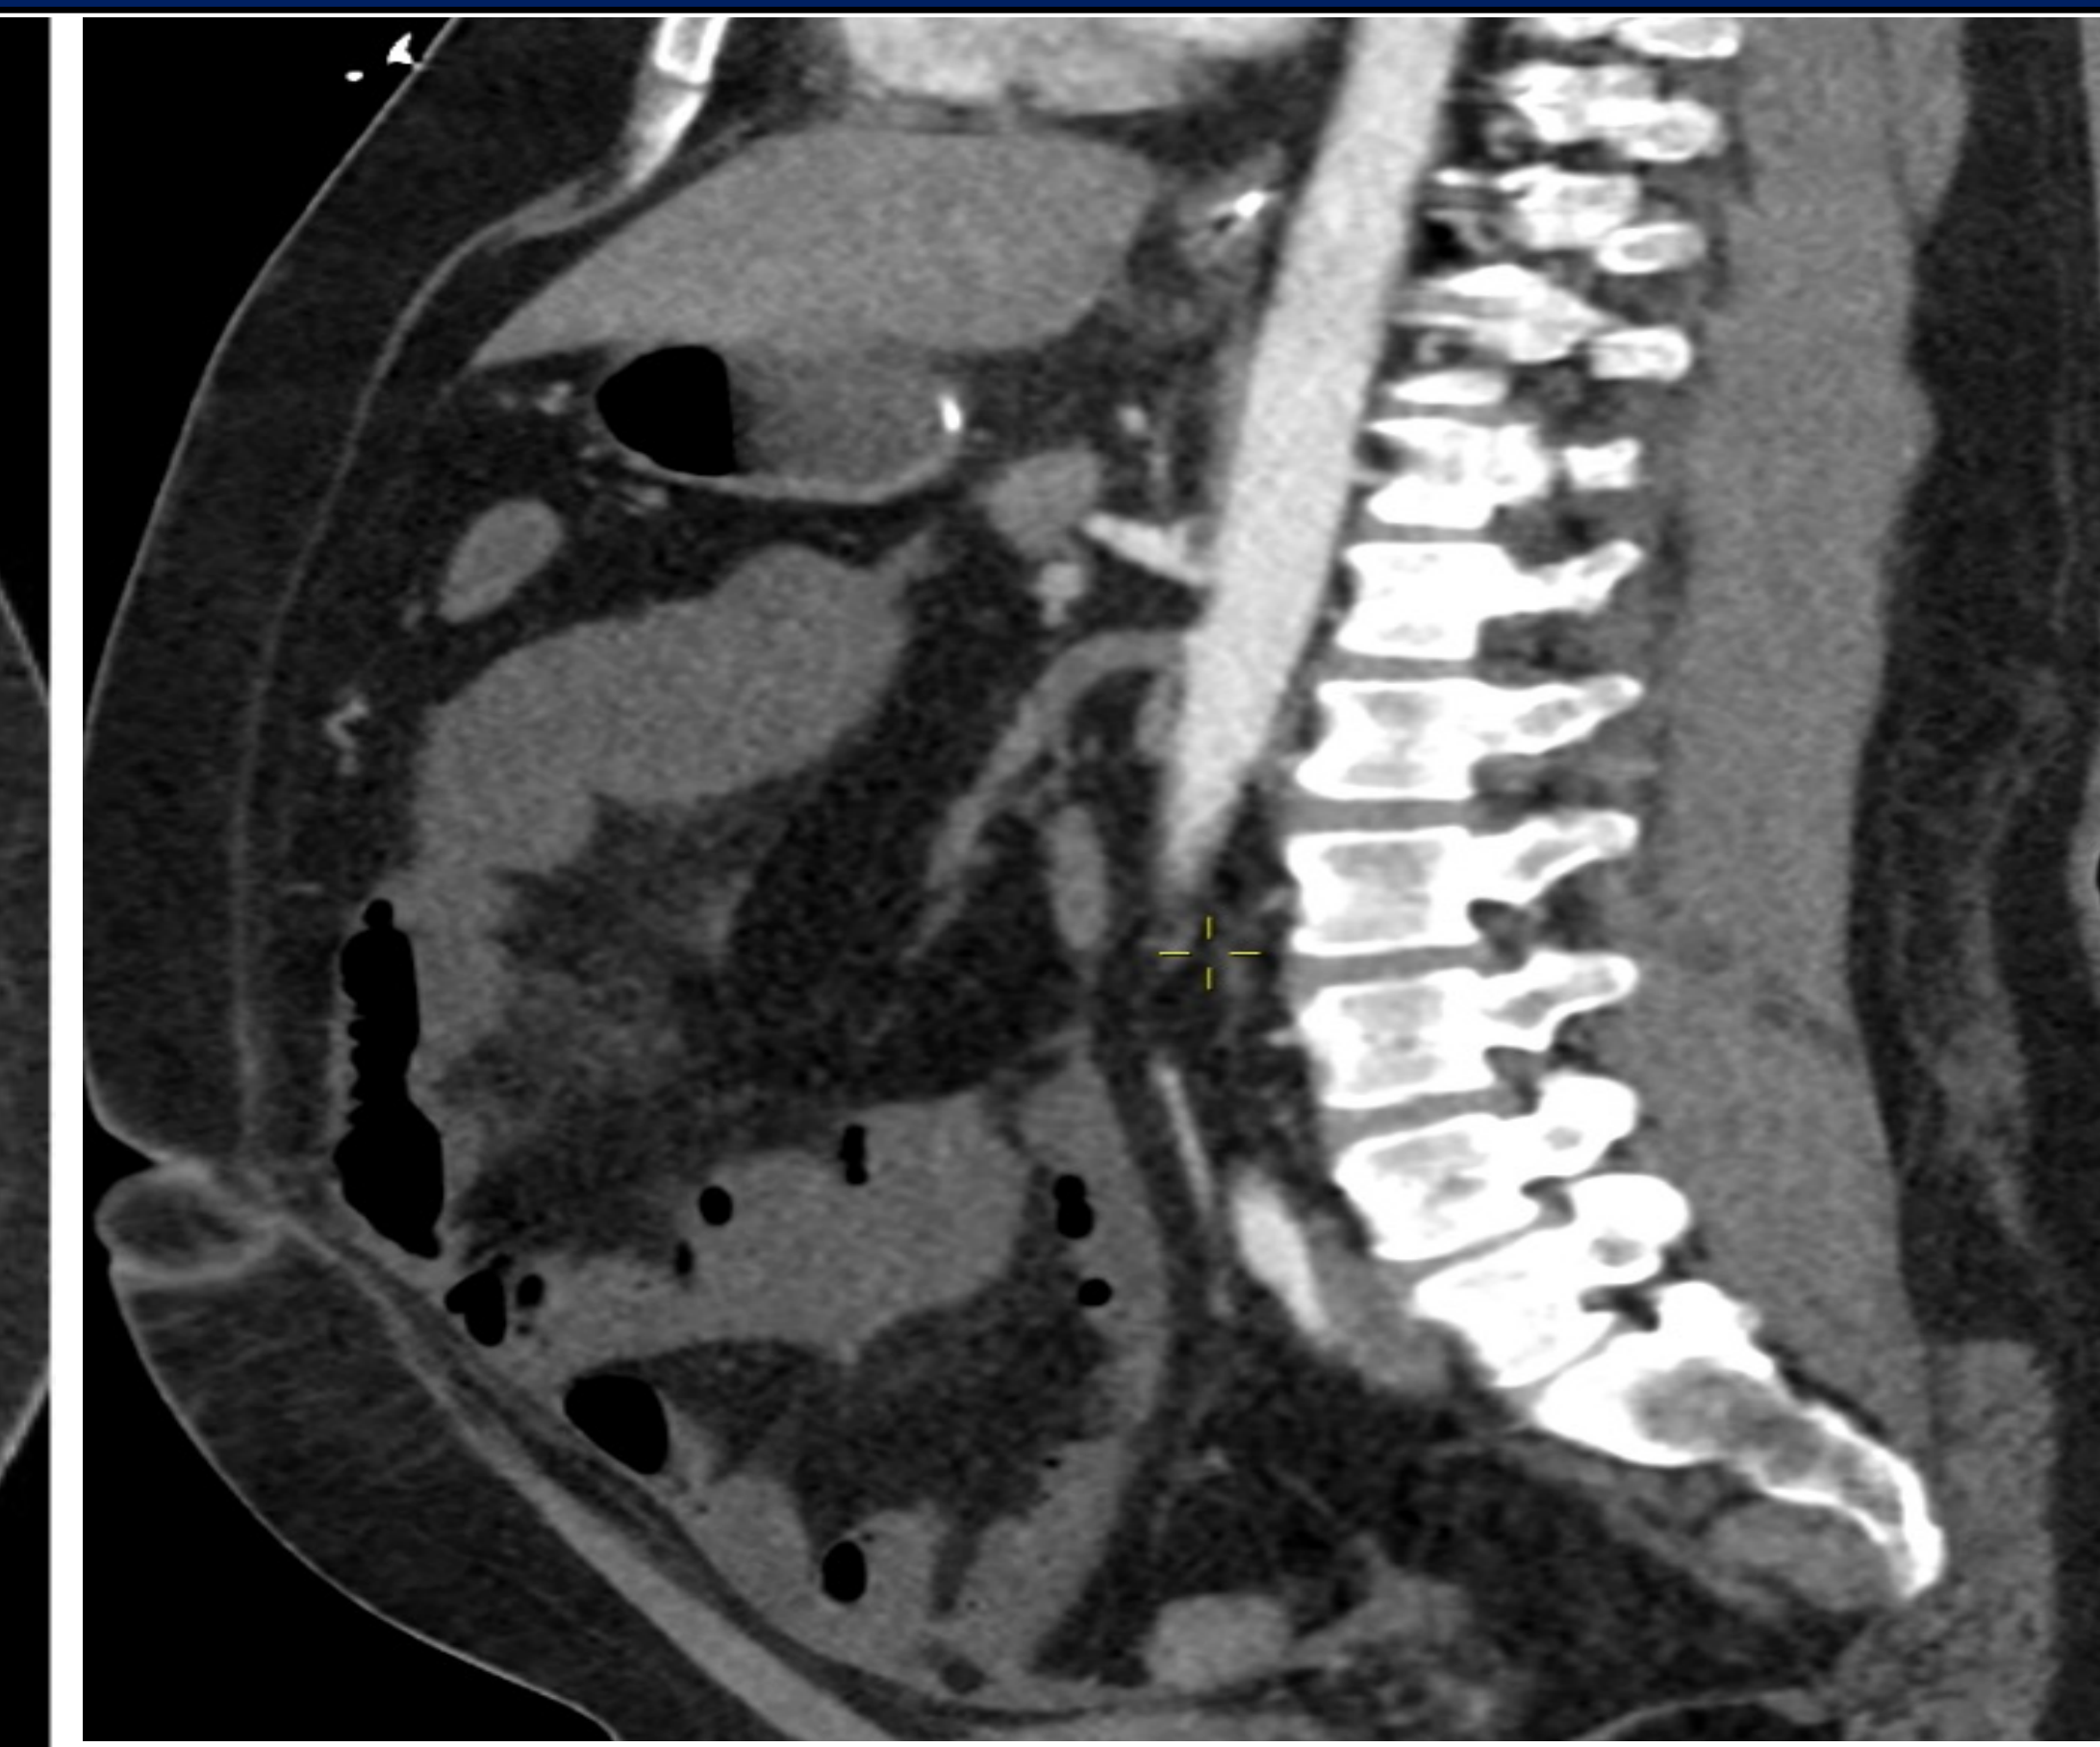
Sagittal images of CTA of abdomen shows thrombus with complete occlusion of the superior mesenteric artery at its origin.
